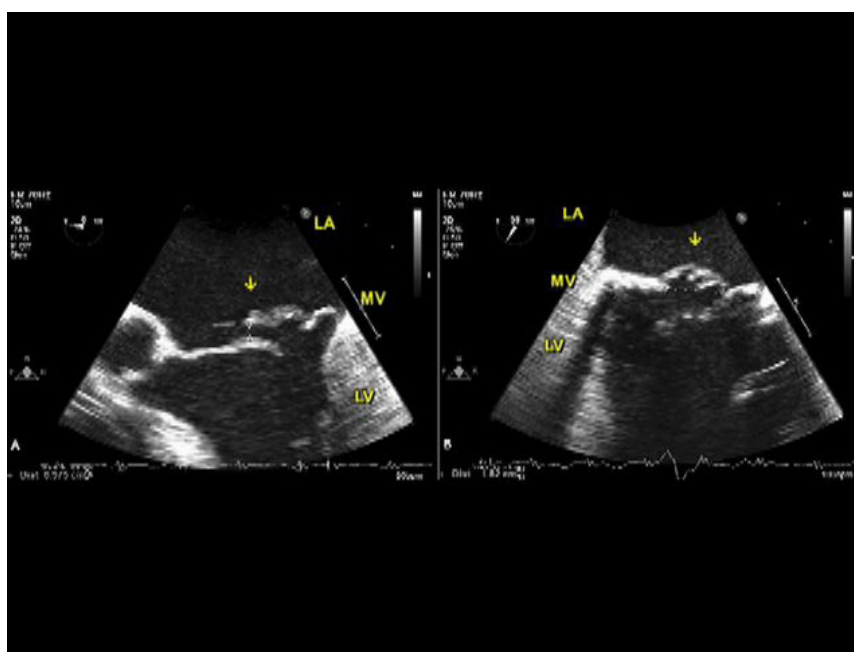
Two-dimensional transesophageal echocardiography demonstrates a flail MV (arrow) in five- and two-chamber views. LV: left ventricle; LA: left atrium; MV: mitral valve. Copyright with Aiman Smer
